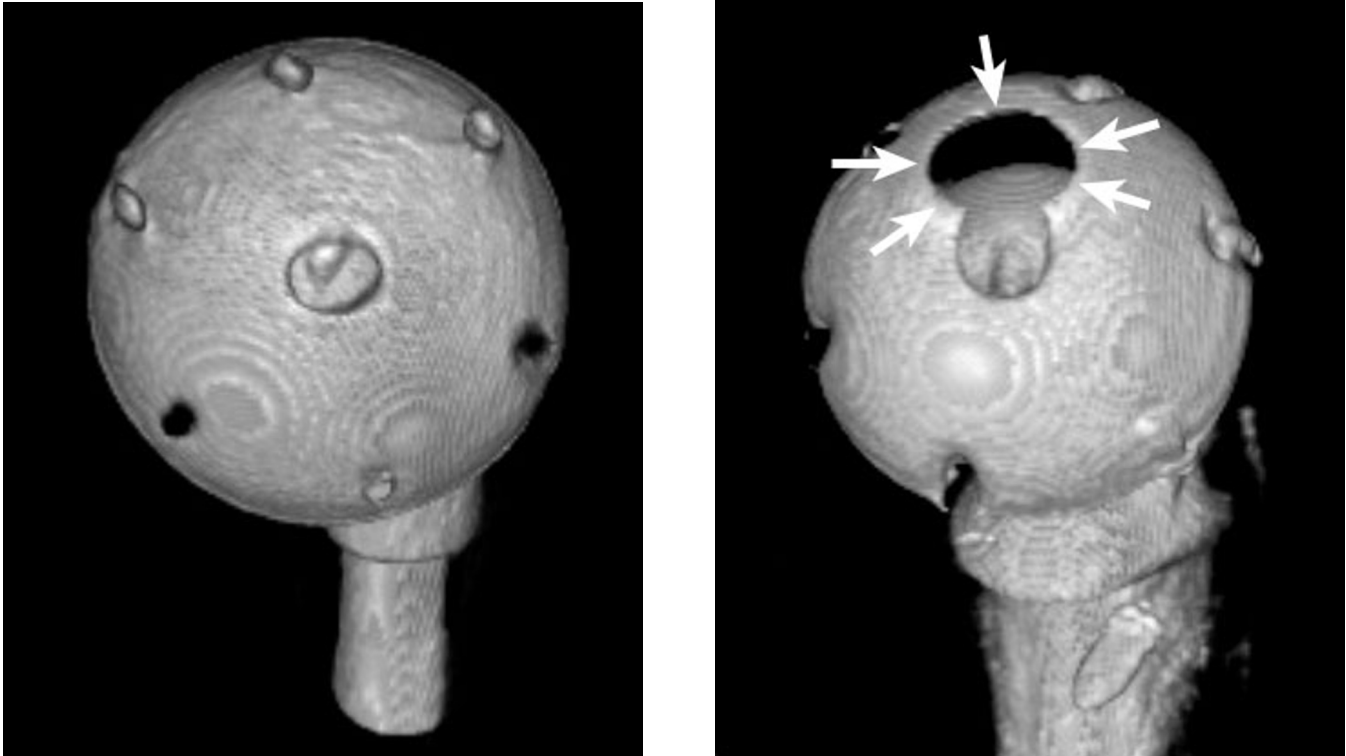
Volume-rendered 3D reformation of CT of prostheses. Left: Medial surface of left acetabular component. Right: Medial surface of the displaced right acetabular component. The abnormal articulation between this component and the ilium has worn a circular hole (arrows) in the component. In addition: [QuickTime 3D movie](#) (893 kB) of both prostheses.
